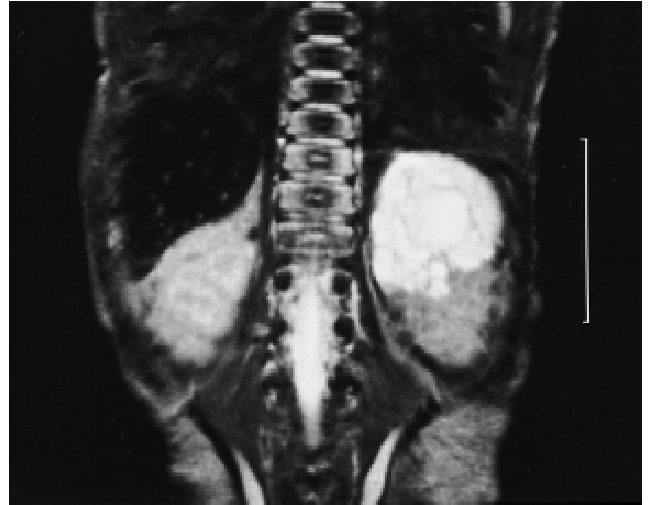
Coronal T2-weighted image: Contents of the cysts hyperintense and homogenous indicating fluid filled cysts. Septae separating the cystic compartments.
